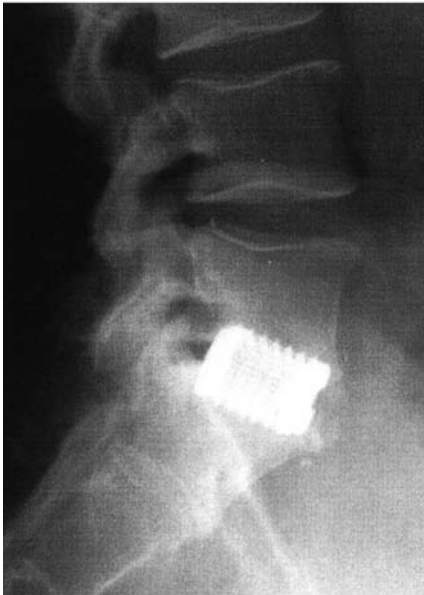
(A) Lateral radiograph of the lumbar spine shows significant disc space collapse and loss of segmental lordosis at the L5–S1 interspace. (B) Anteroposterior and (C) lateral radiographs after surgery show two threaded cortical bone dowels in place in the L5–S1 disc space. The threads engage the vertebral end plates and help to stabilize the intervertebral motion segment. At the operative level, normal disc space height and segmental lordosis has been restored.
